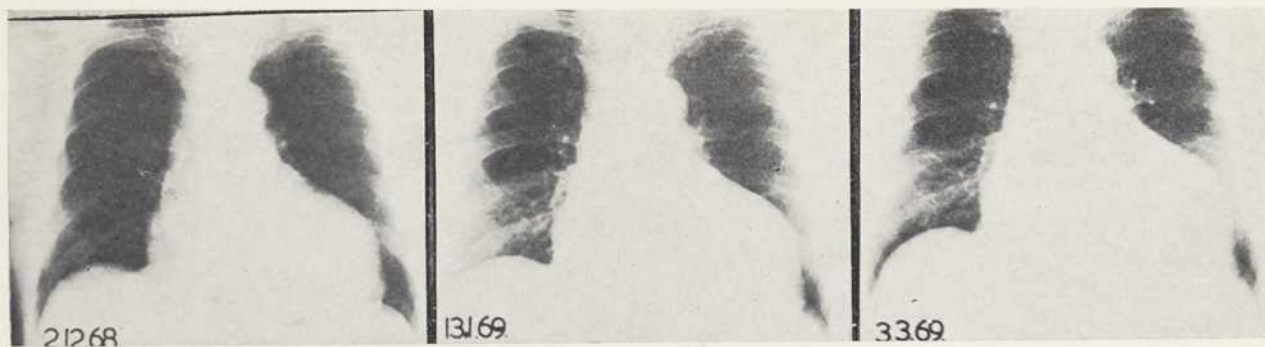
Serial X-rays in patient P.B. show progressive increase in heart size
